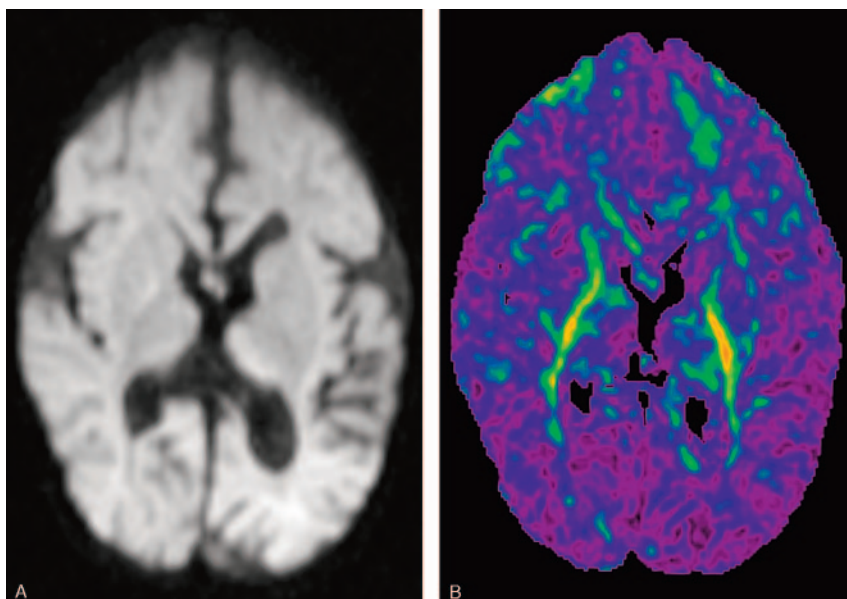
MR images at the age of 17 months.
